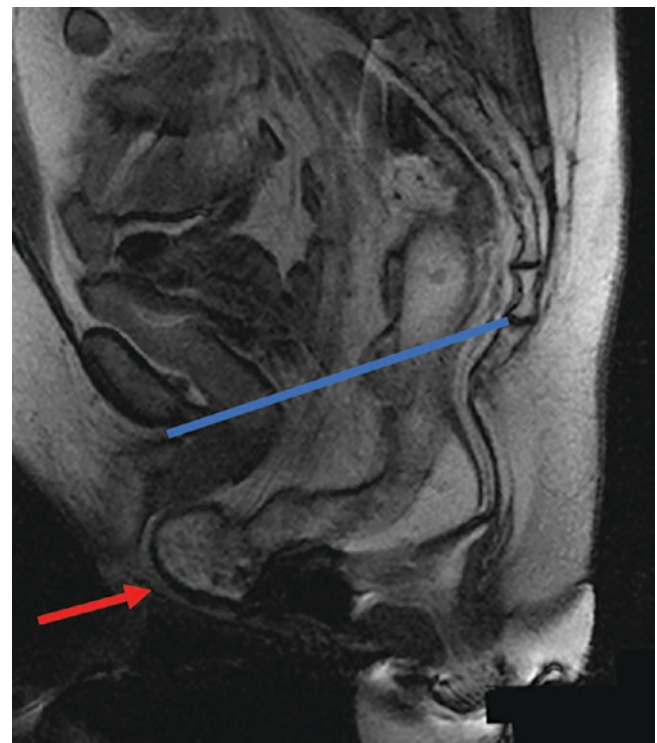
Dynamic MRI in evacuation phase showing an enterocele (red arrow). There is herniation of small bowel loops in the middle compartment, between the bladder and vagina and rectum, due to rupture of the endopelvic fascia and the retovaginal septum. Blue line represents pubococcygeal line
